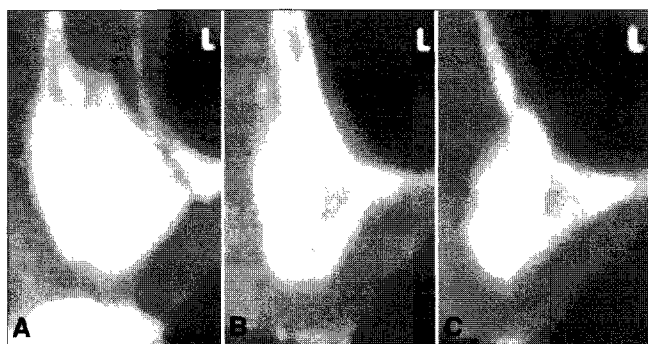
Ten weeks (75 days) after surgery, a preimplant computed tomography scan showed that the graft seemed integrated. There was a complete radiological homogeneity between the grafted bone and the remaining alveolar walls.
